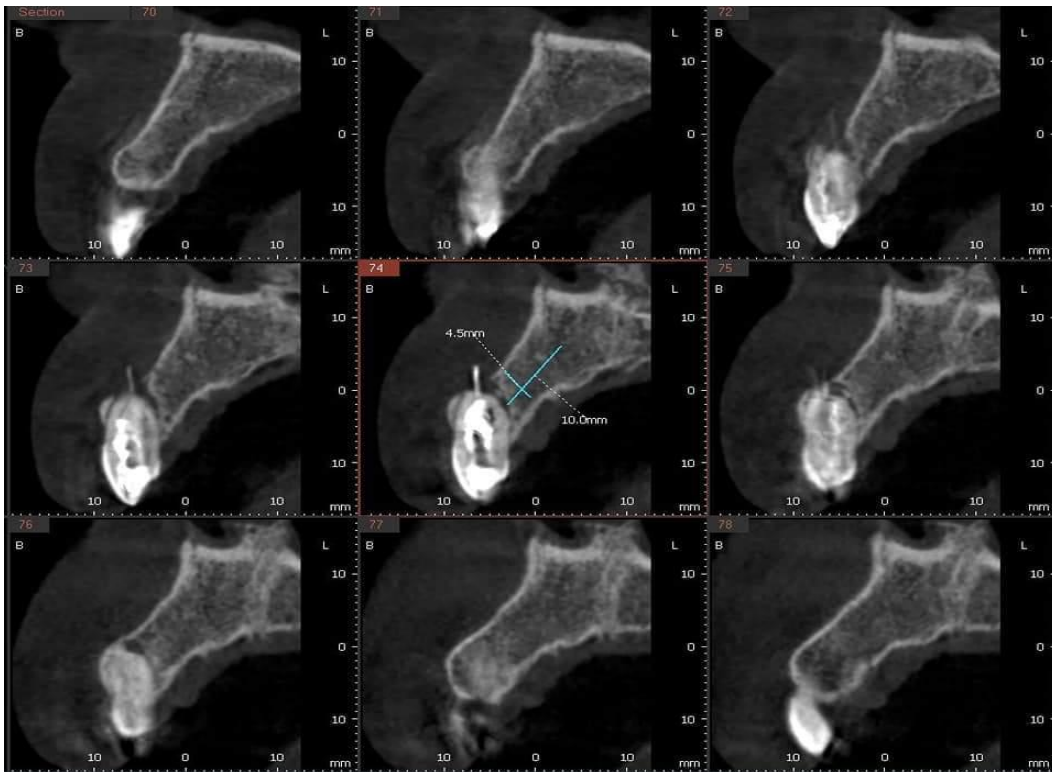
Cone Beam Computed Tomography: Sagittal view
